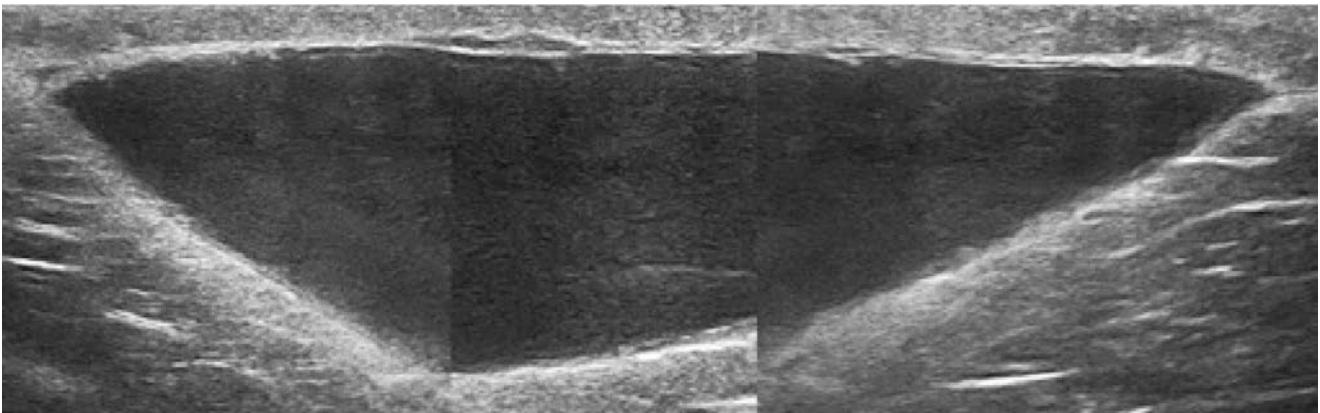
Hip soft tissue hematoma. Female patient, 1 month after hip trauma, the local lateral bulge of the joint, no pain. Ultrasound detects a huge hematoma in subcutaneous tissue
